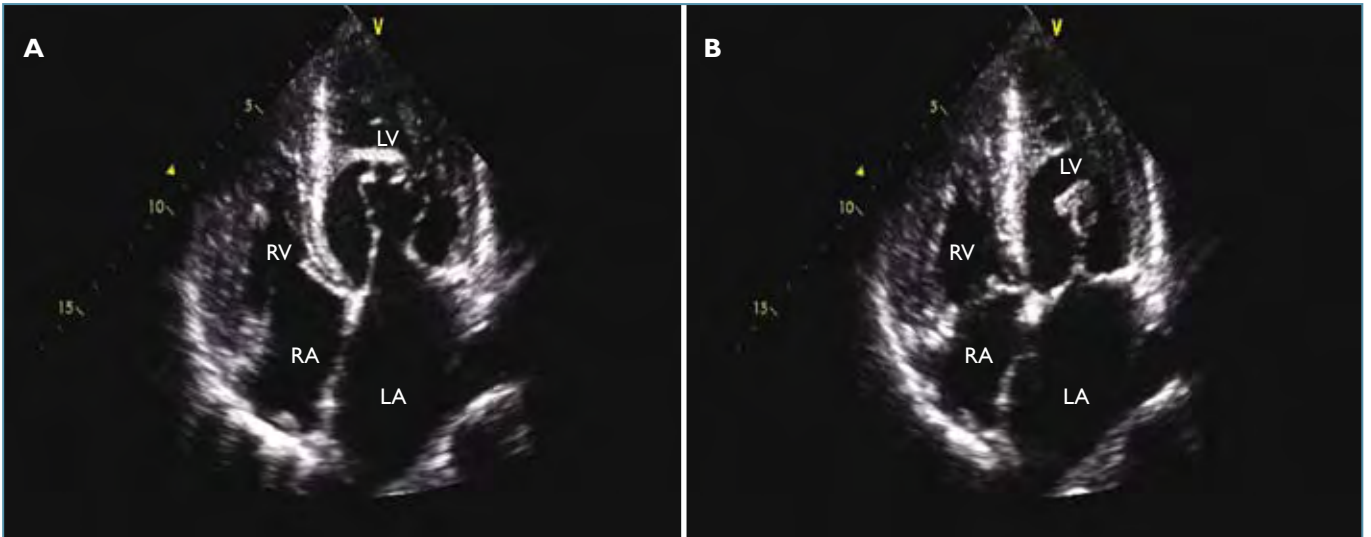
Transthoracic echocardiography demonstrating the parachute mitral valve. A: apical four chamber view in diastole; B: apical four chamber view in systole.
